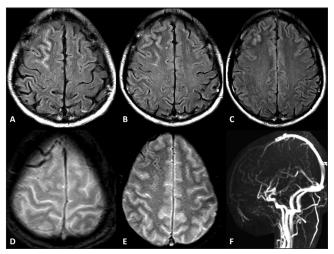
(a-c) Axial FLAIR MR image showing focal subcortical T2 hypointensity in the right frontal lobe, FLAIR hyperintensity in corresponding sulci (d and e) GRE images showing blooming in superficial cortical veins and within sulci (f) MR venogram showing occlusion of the anterior 1/3rd of the superficial sagittal sinus
